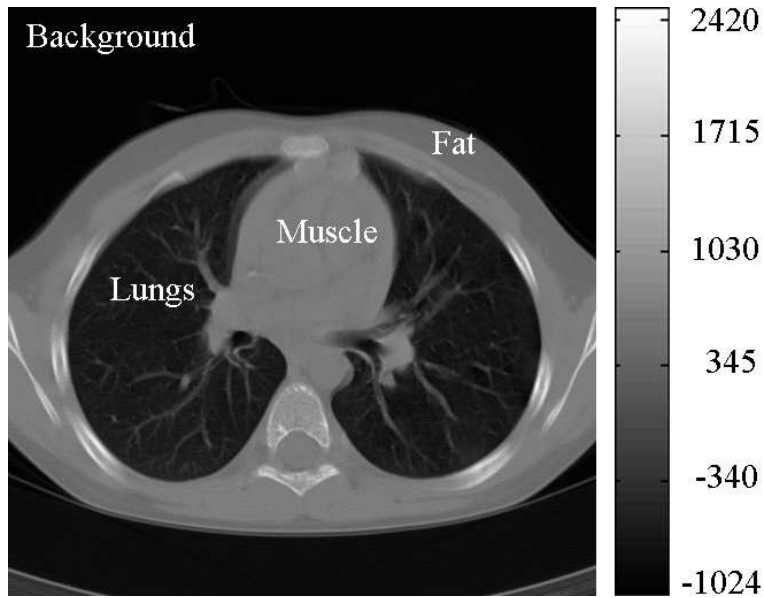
Original CT slice and tissues localization. Intensity values are given in HU.
